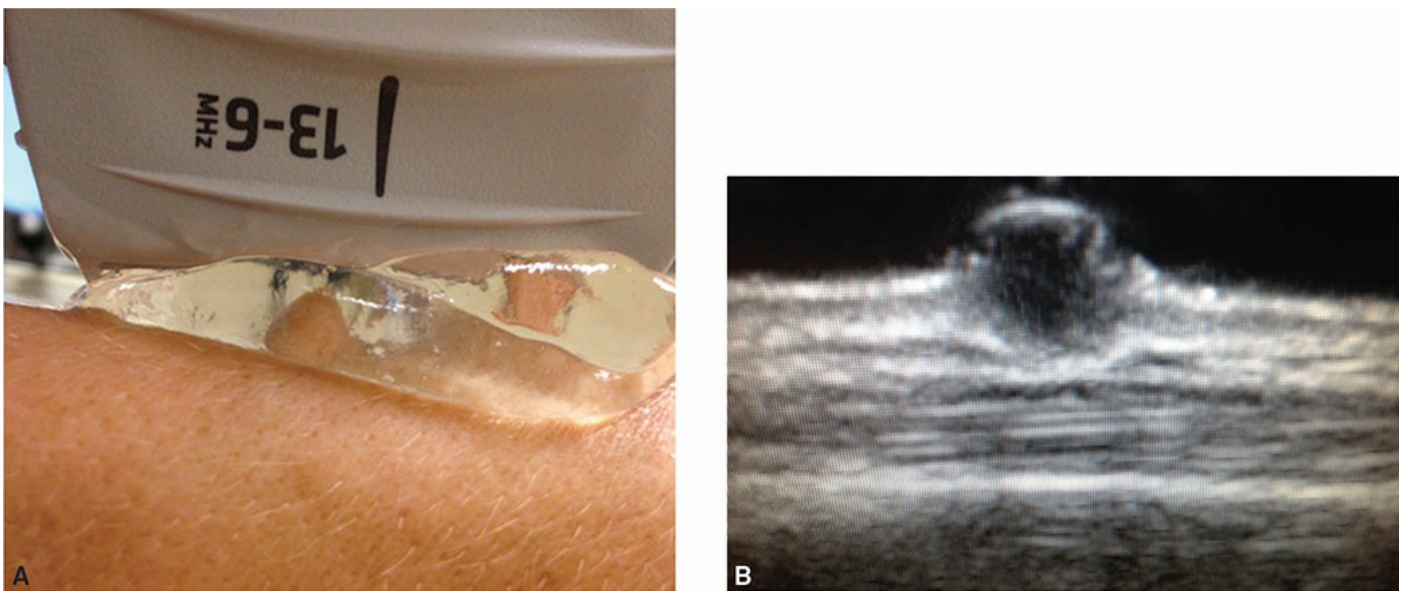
A: Ultrasound gel bridge. B: Corresponding clinical image.
